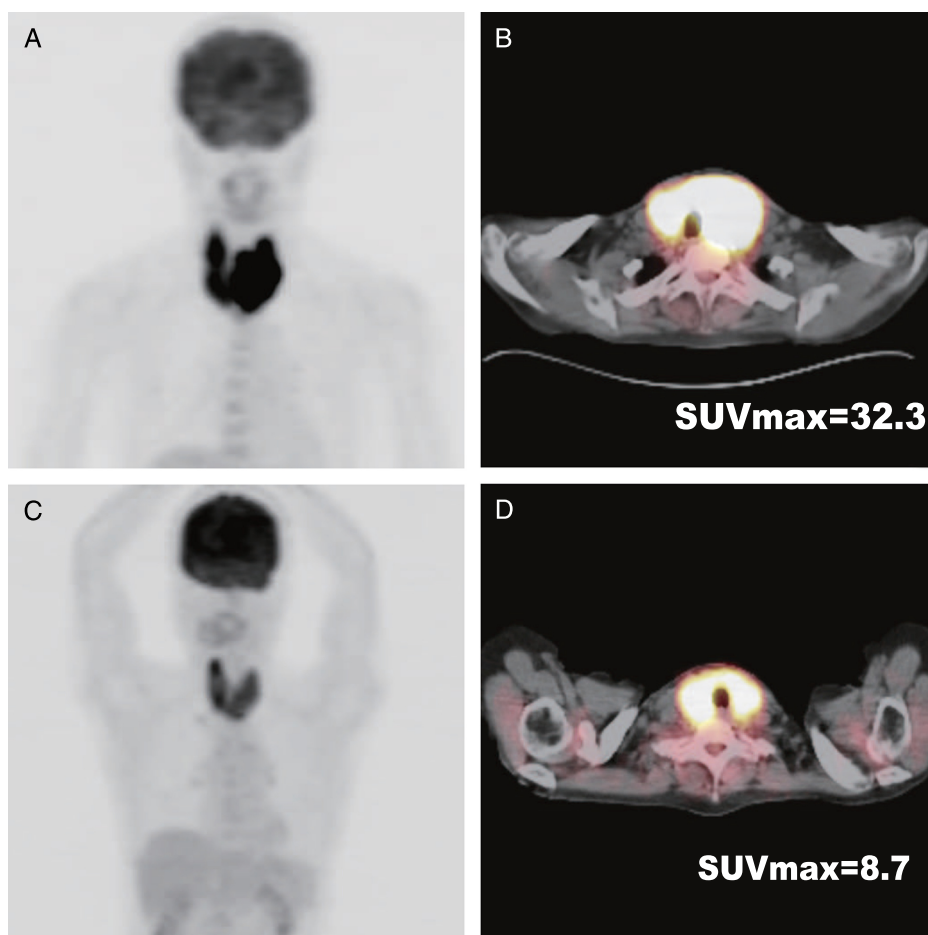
Maximum-intensity-projection image (A) and transaxial fused image (B) with diffuse ^{18}F -FDG uptake in a primary thyroid lymphoma patient (C, D) and those in a chronic thyroiditis patient. It is difficult to distinguish between the primary thyroid lymphoma and chronic thyroiditis visually. However, the maximum standardized uptake value (SUV_{max}) was significantly different between the 2 lesions.
